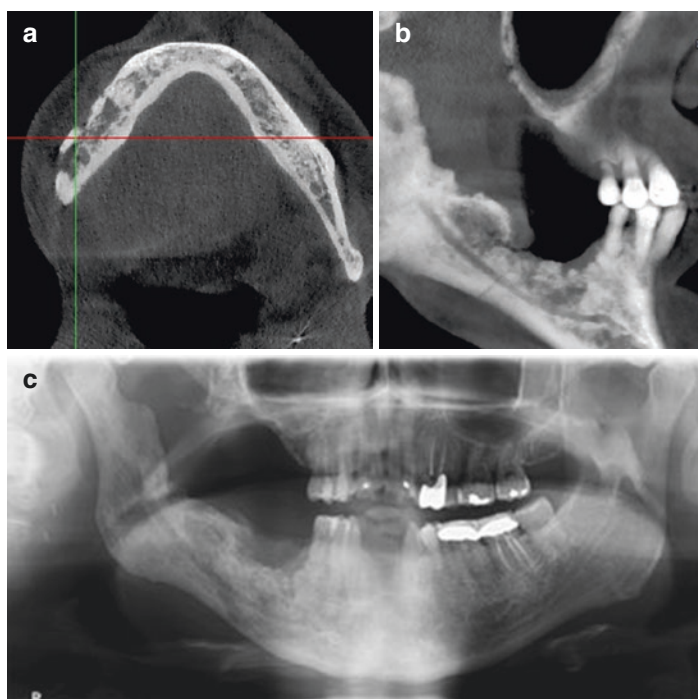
(a) Axial view of CT scan of the mandible demonstrating significant osteolytic change. (b) Sagittal view of the mandible on CT showing osteolytic changes in body region. (c) Panoramic radiograph showing osteolytic changes at superior border of body region
